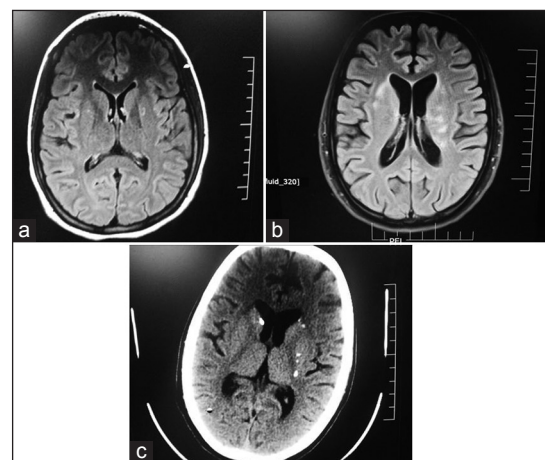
MRI (a) Diffuse atrophy, (b) Diffuse atrophy with White matter signal changes (c) CT brain showing diffuse atrophy with old calcified granulomas
